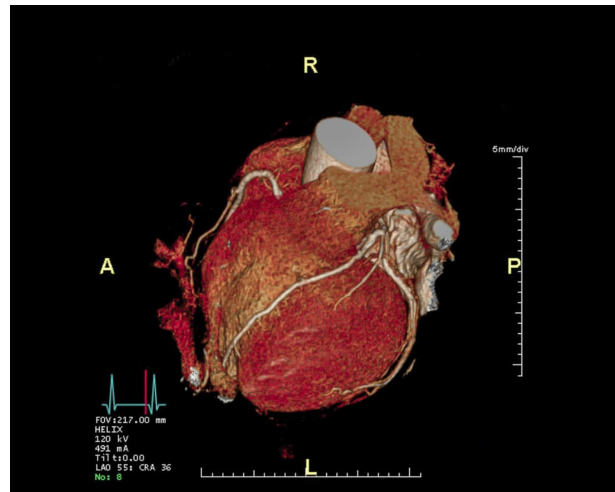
Example of a three dimensional cardiac CT [8]
